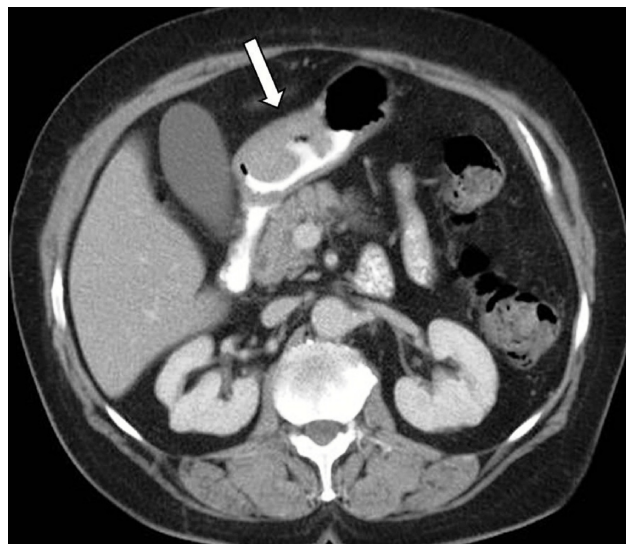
Computed tomography of the upper abdomen.
